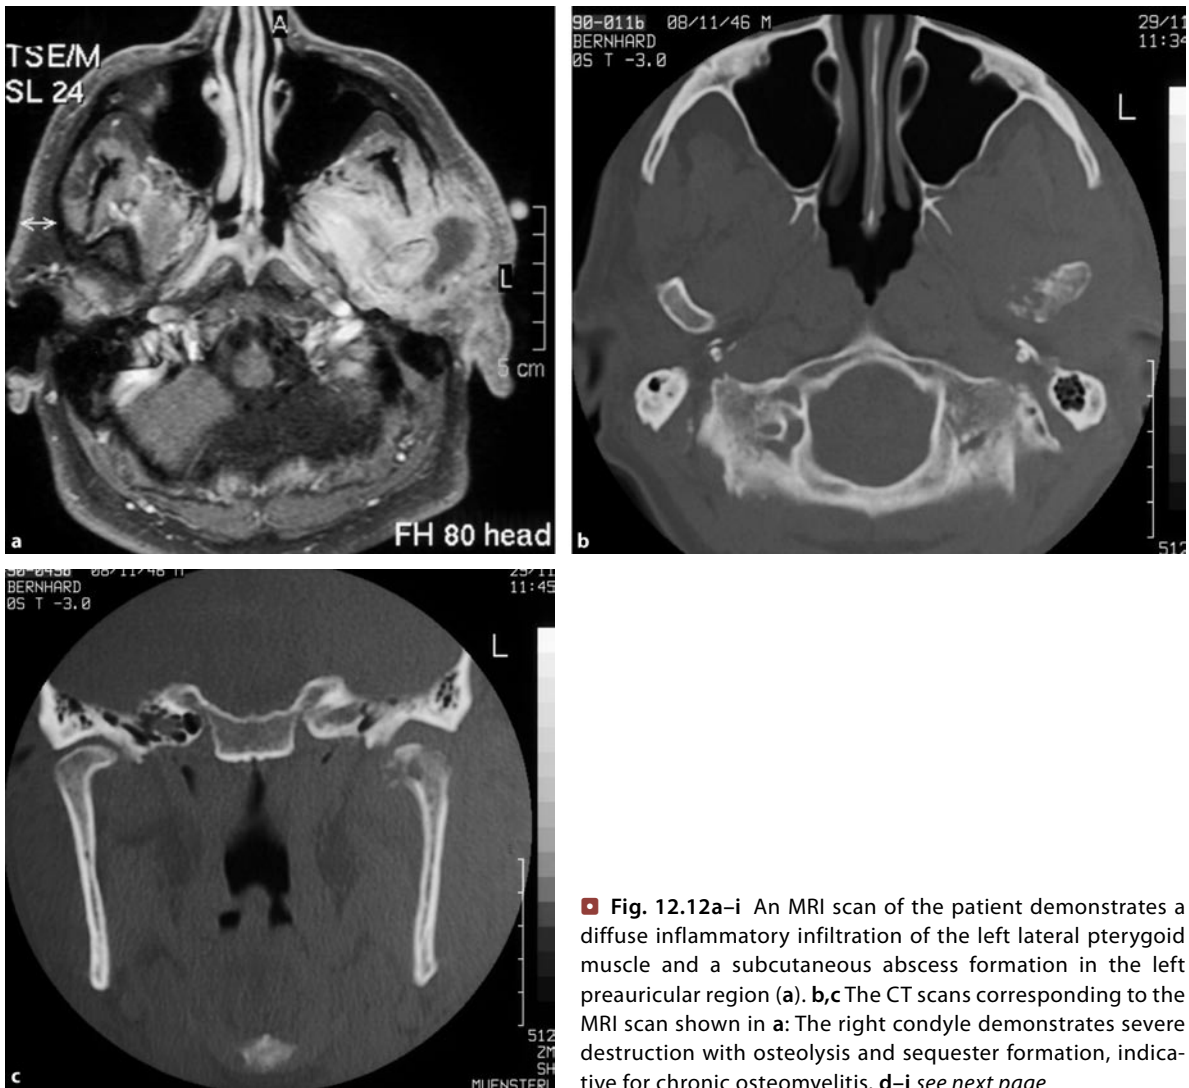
An MRI scan of the patient demonstrates a diffuse inflammatory infiltration of the left lateral pterygoid muscle and a subcutaneous abscess formation in the left preauricular region (a). b,c The CT scans corresponding to the MRI scan shown in a: The right condyle demonstrates severe destruction with osteolysis and sequester formation, indicative for chronic osteomyelitis. d–i see next page
